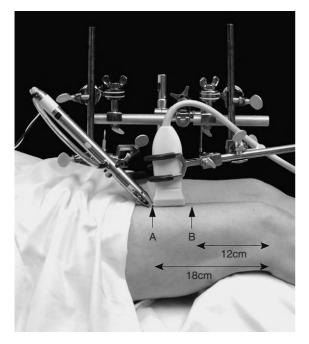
• Method used for ultrasound elasticity imaging during robotic acupuncture needling • An acupuncture needle is inserted and manipulated using a robotic acupuncture needling instrument and an ultrasound cine-recording is acquired during the needle manipulation. Reprinted with permission from Langevin HM, Konofagou EE, Badger GJ et al. (2004) Tissue displacements during acupuncture using ultrasound elastography techniques. Ultrasound Med Biol 30: 1173-1183.
